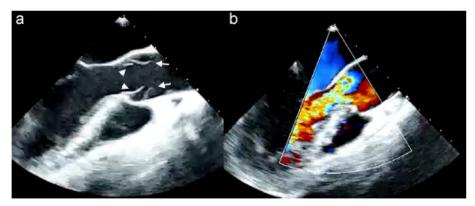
Preoperative transesophageal echocardiography evidently shows aortic dissection localized in the aortic root. (A) An intimal flap (arrows) originates just above the aortic valve (arrowheads). (B) The aortic dissection causes severe aortic regurgitation.
